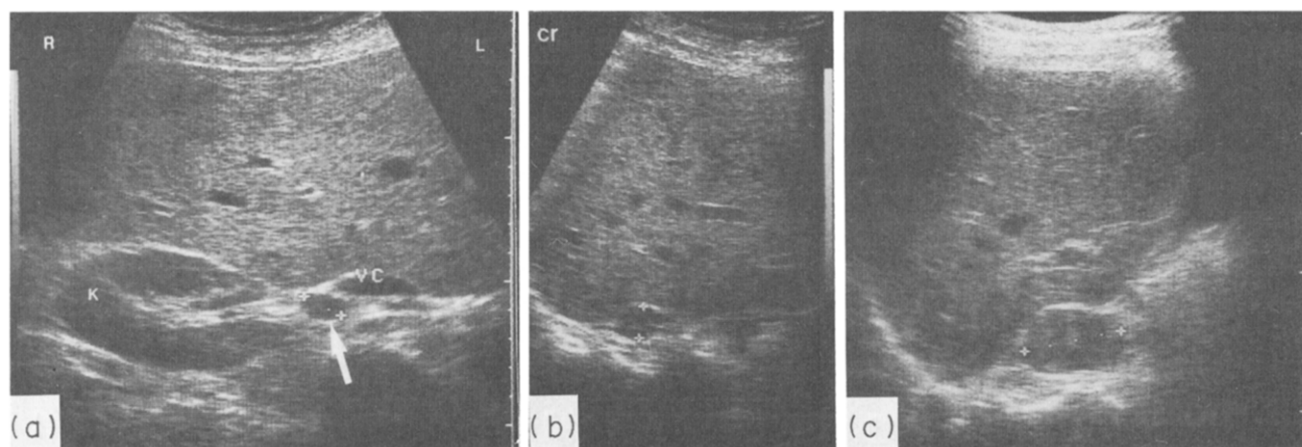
Subcostal (a) and intercostal (b) sonogram in a patient with lung cancer shows a small round, hypoechoic, isolated adrenal lesion at initial presentation (arrow). Follow-up examination 5 weeks later (c) revealed tumour progression. k = kidney, vc = vena cava.
